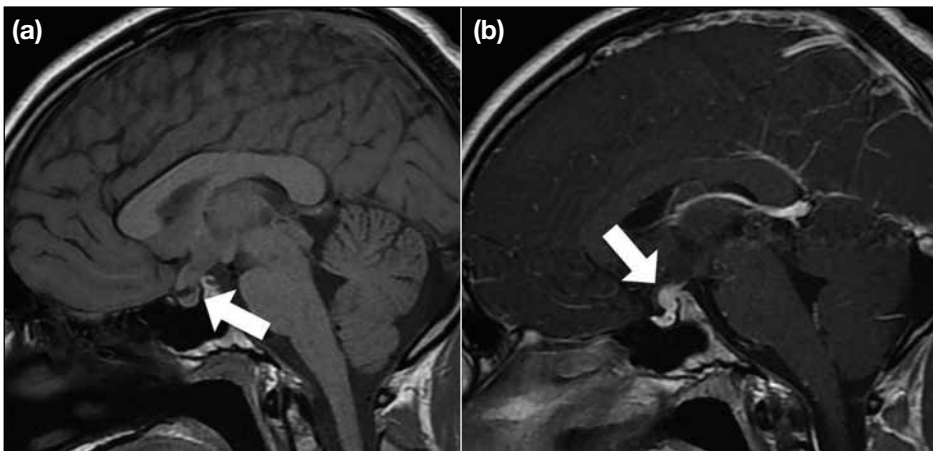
Lymphocytic hypophysitis. The case demonstrates the lesion presenting as thickening of the pituitary stalk with tapering in the sella; there is loss of the normal bright signal (arrow) in the neurohypophysis on sagittal T1-weighted image (a). Marked enhancement of the lesion (arrow) is found on enhanced sagittal T1-weighted image (b).
